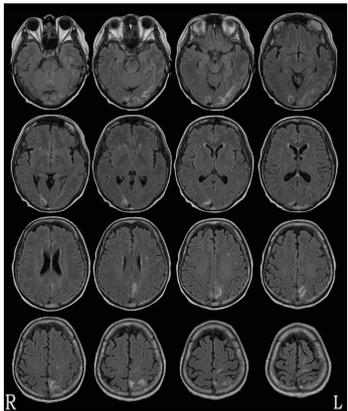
MRI scans of patients SL (a), KC (b), and control patient ES (c).
